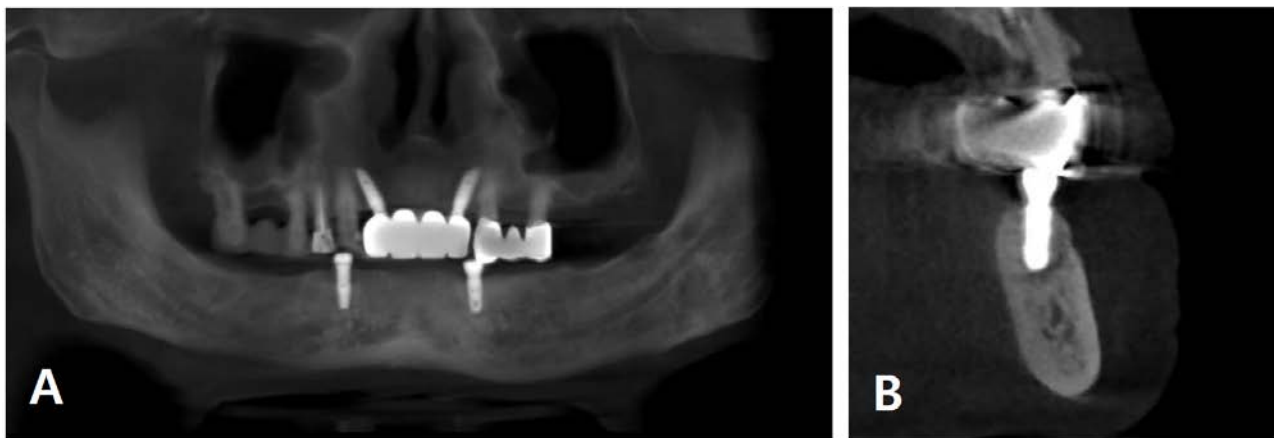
CBCT image after #33 implant installation with shorter length fixture. (A) Panoramic view. (B) Paraxial view.
